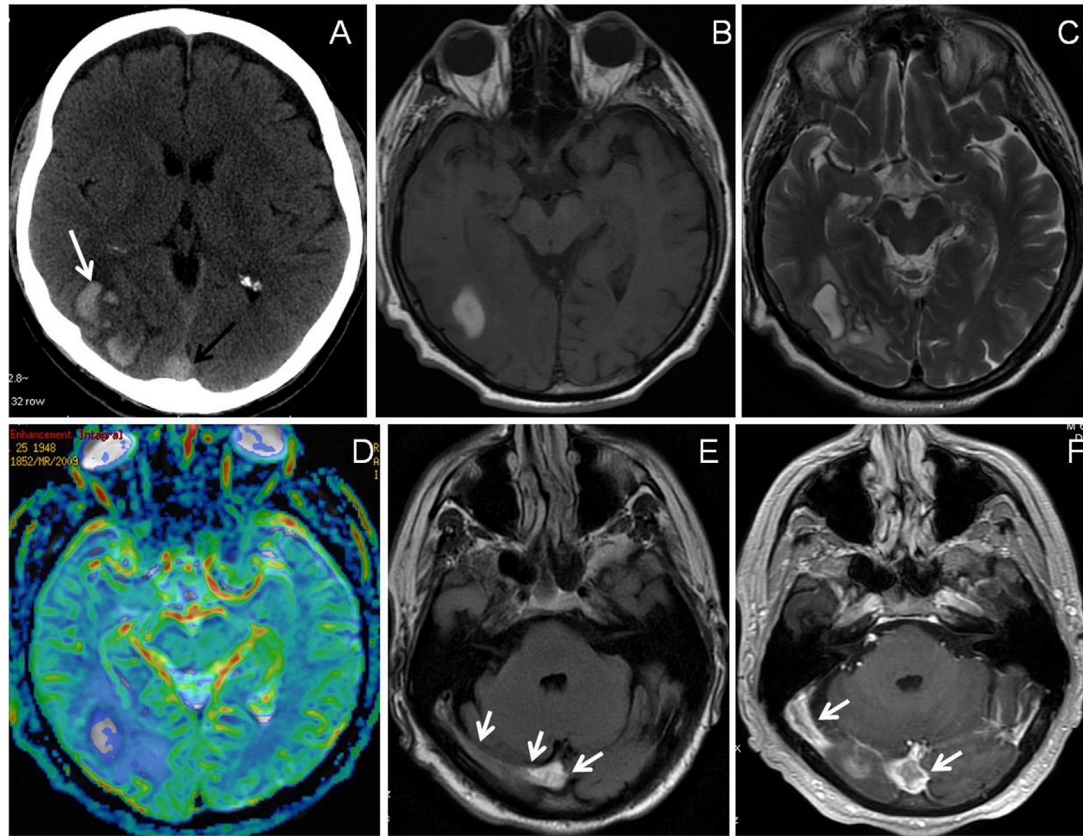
CT image (A) showing hemorrhagic venous infarction within right occipital lobe (white arrow) and hyperdense superior sagittal sinus indicating CVT (black arrow). T1-weighted (B) and T2-weighted (C) MR images showing hyperintense right occipital hematoma surrounded by edema without hyperperfusion on perfusion map (D). FLAIR MR image (E) showing hyperintense right transverse sinus indicating CVT (arrows) and post contrast T1-weighted image (F) showing a filling defect in the confluence of the sinuses and in the right transverse sinus indicating thrombus (arrows).
